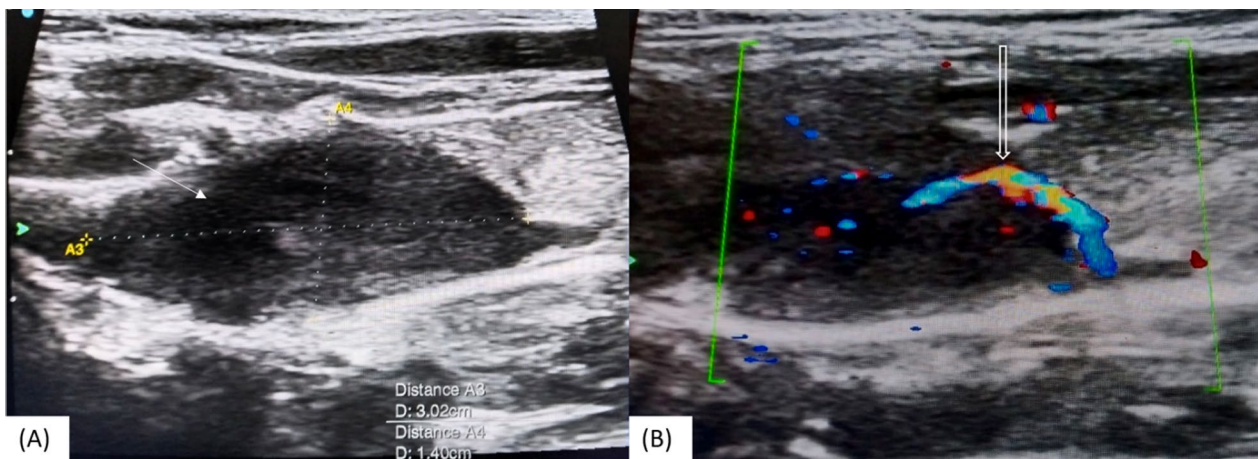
Neck ultrasonography images in the same patient. A Depicts a well-defined, erosive, hypoechoic lesion of 3.02×1.4 cm in the left inferior parathyroid gland suggestive of a solitary parathyroid adenoma (white arrow). B A single polar vessel is seen supplying the lesion (white outline arrow), representing its arterial vascularity
